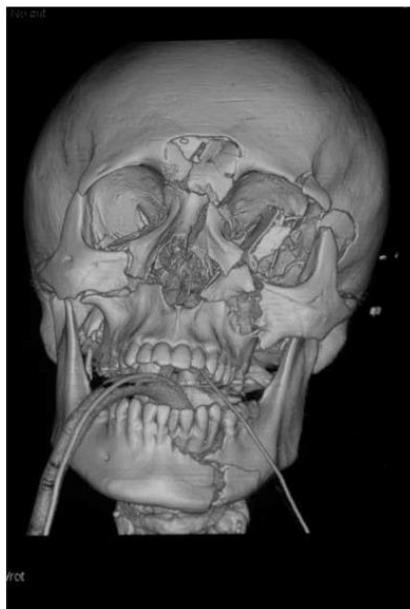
Three-dimensional computed tomography (3D CT) reconstruction of the midface demonstrating Le Fort fracture lines and disruption of the maxillary buttresses .¹³
